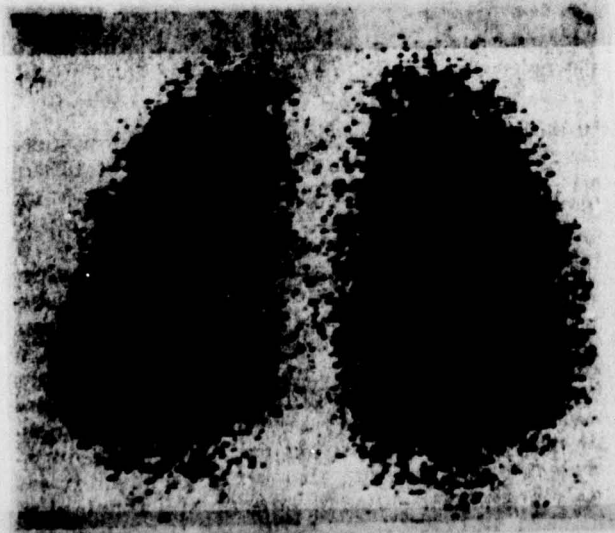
Normal lung ventilation scintigram with posteroanterior view (PA).
